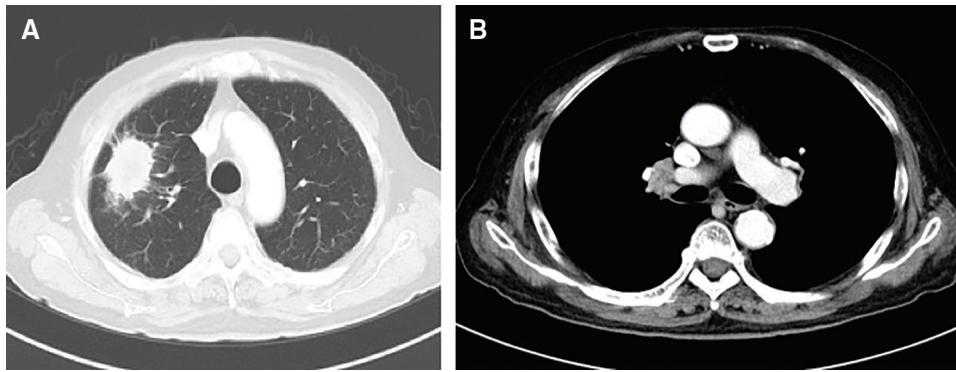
Chest CT showing a 50-mm tumor in the upper lobe of the right lung (A) and swollen lymph node in the hilar region of the lung (B). CT: computed tomography
